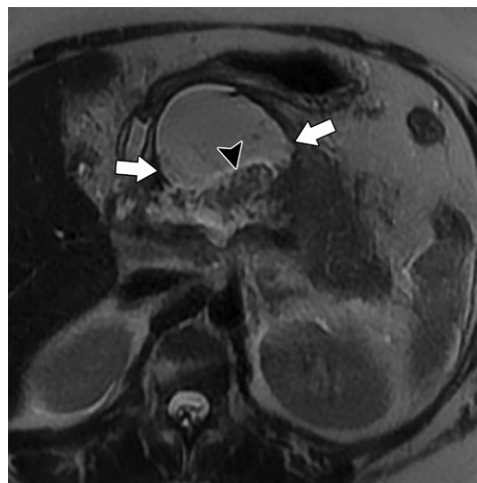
Peripancreatic fluid collection in a 48-year-old woman, 3 weeks after the onset of pancreatitis. Axial T2-weighted MR image shows a pancreatic and peripancreatic T2-hyperintense collection (arrows) containing fluid and nonliquefied debris, including necrotic pancreatic neck and body parenchyma (arrowhead), consistent with ANC.
